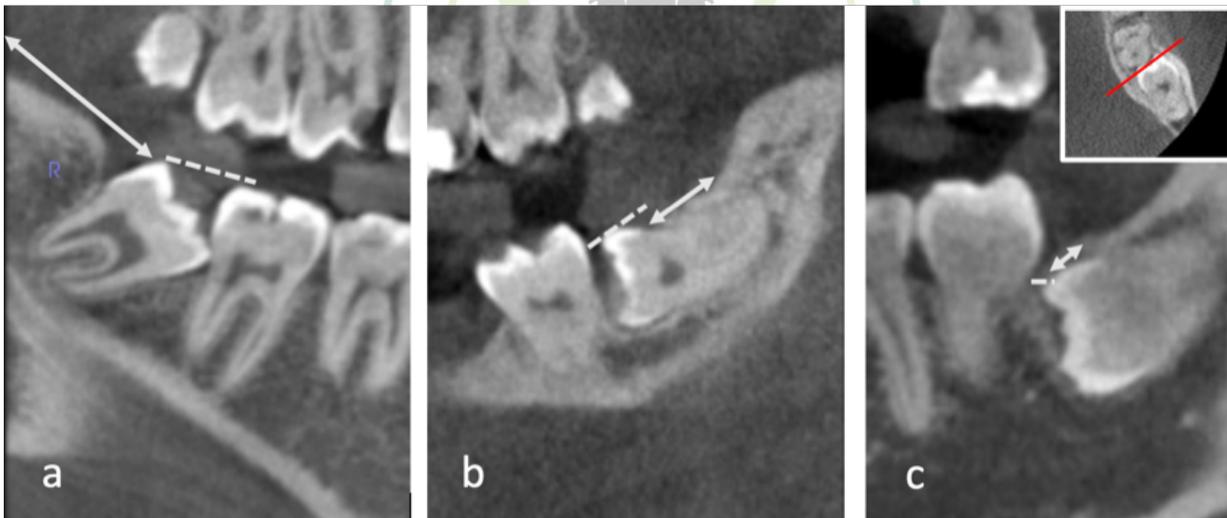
Three cropped and reformatted panoramic CBCT sections of impacted mandibular third molars. The double arrow represents class and the dashed line position. (a) Class I: enough space from the mandibular molar to the ramus; Position A: height of the highest point of the impacted third molar is at the level of the occlusal plane of the second molar. (b) Class II: short space from the mandibular molar to the ramus; Position B: height of the highest point of the impacted third molar is below the level of the occlusal plane of the second molar. (c) Class III: minimum space from the mandibular molar to the ramus; Position C: height of the highest point of the impacted third molar is at the cemento-enamel junction of the second molar, the “axial view” shows that the impacted tooth is within the bulge of the ramus.
